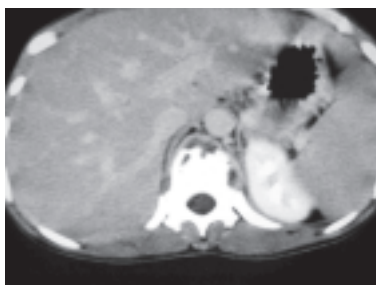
Enhanced axial CT scan taken at the level of T12 vertebra.
